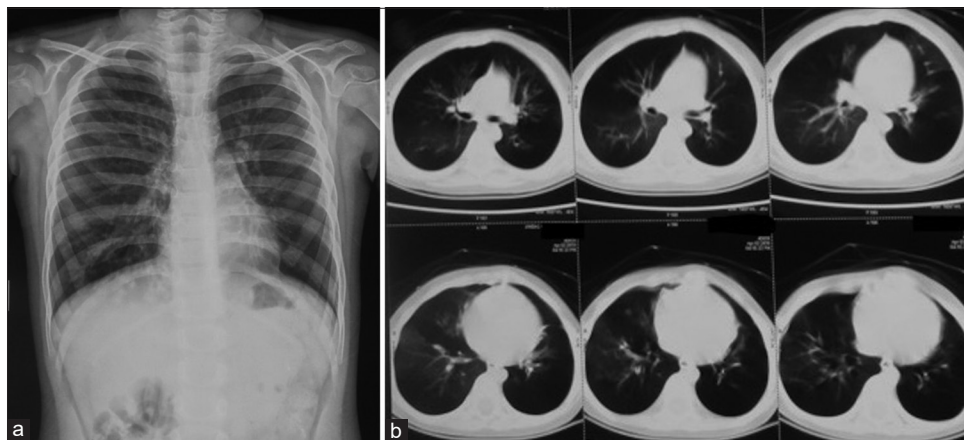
Chest X-ray and computed tomography chest of case 6: (a) Chest X-ray showing hyperinflation, (b) computed tomography chest is showing mosaic attenuation and peribronchial thickening
